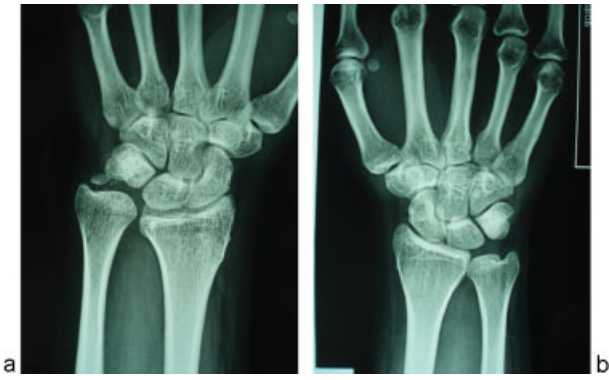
(a) Radiograph showing 1 cm ulnar positive variance and ulnar styloid nonunion. (b) Radiograph of normal contralateral wrist.
